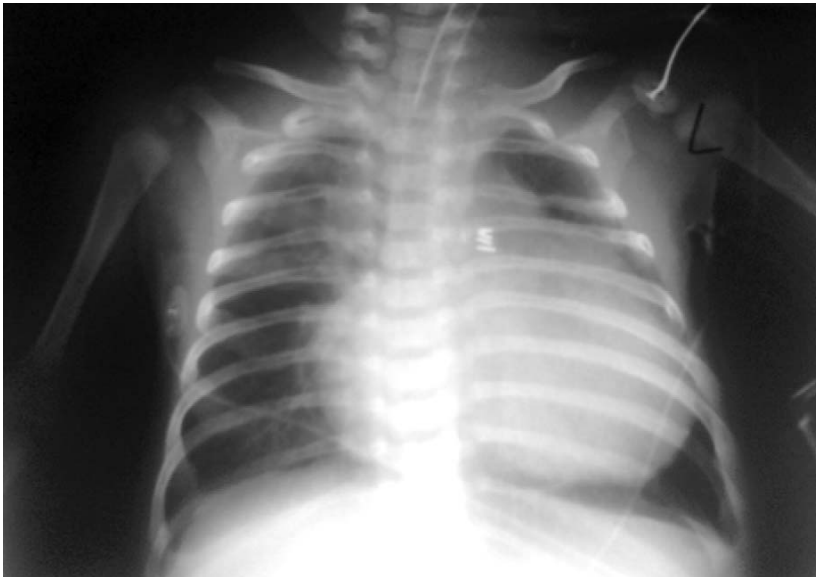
Chest x-ray of the infant on prostaglandin E1 infusion after admission to the intensive care unit.
